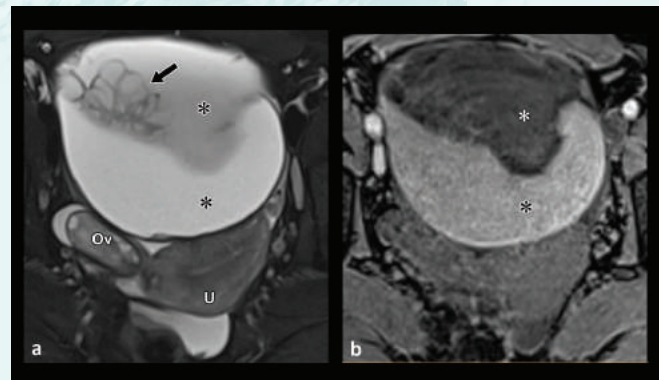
Borderline Mucinous Tumour: (a) T2-w transverse MRI scan showing a left ovarian tumour containing mucous of different signal intensities (*). Note the cluster of cysts (arrow) contained within the lesion. The normal right ovary (Ov) and uterus (U) are also shown. (b) T1-w transverse non-enhanced MRI scan shows low T1 signal in the mucous that showed high T2 signal in (a).
